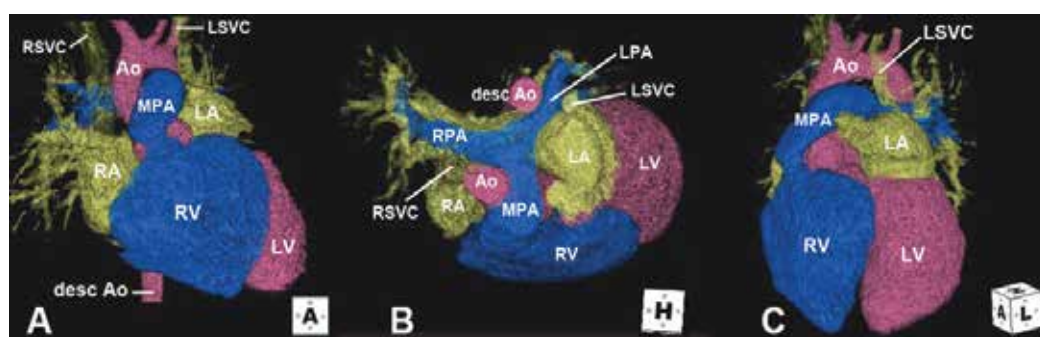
Three-D CT reconstruction of the patient in Figure 6 seven years after ASO (A, B & C) showed the natural spiral relationship of the great arteries with harmonic growth of their branches. (desc = descending, LA = Left Atrium, R or L SVC = Right or Left Superior Vena Cava, other Abbreviations see Figure 5 & 6. Reproduced with permission from Chiu et al., 2010)
